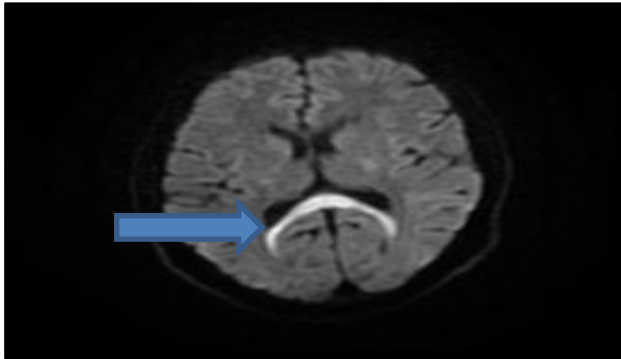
Axial T2W MRI of brain shows symmetrical areas of hyperintensity involving splenium of corpus callosum (arrow).
